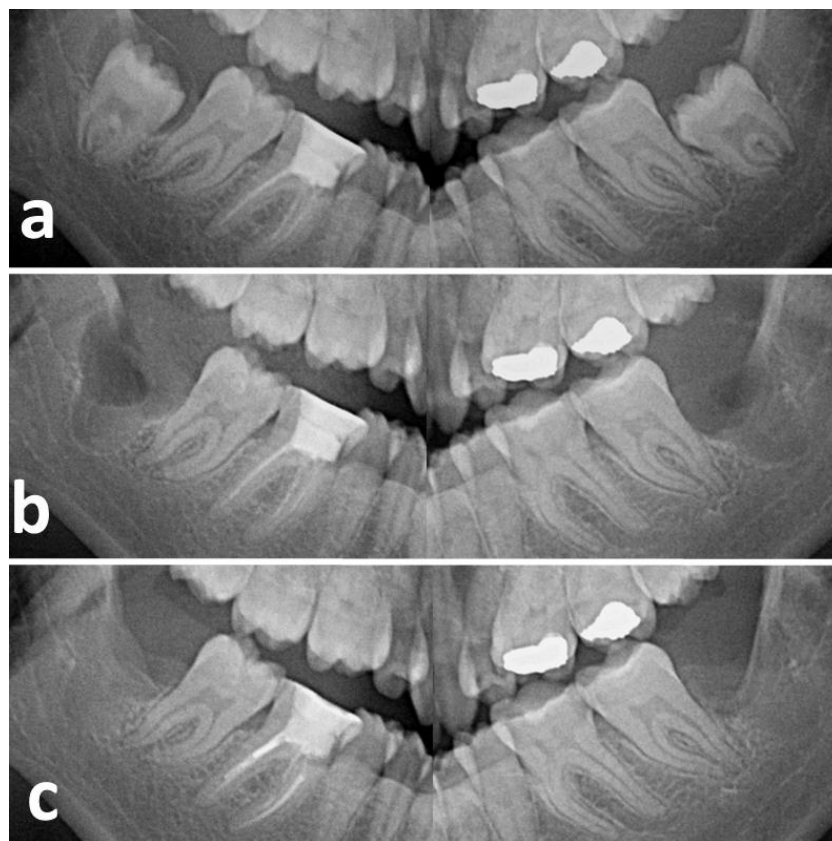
Panoramic radiograph of surgical site of patient with bilateral impacted mandibular third molars : (a) before extraction, (b) immediately after the extraction, (c) after 4 months.
